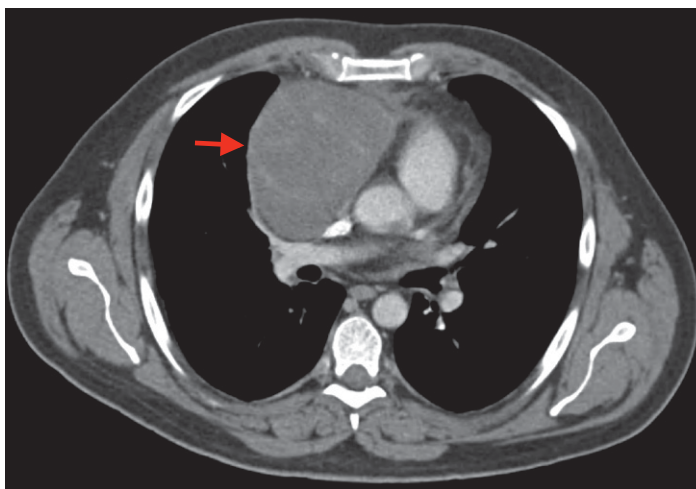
Computed tomography scan of the chest revealed a large, anterior mediastinal mass (red arrow).
